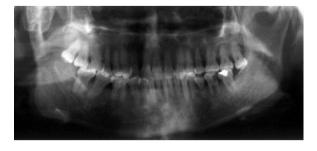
Radiographic image showing a bony mass on the right condyle.
